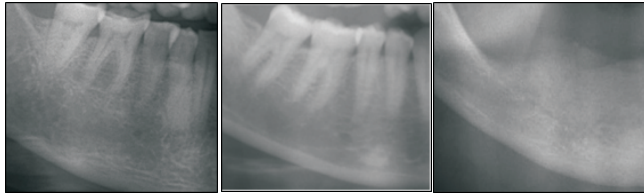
Radiographs depicting qualitative MCI. 1a: C1 category, 1b: C2 category, 1c: C3 category
